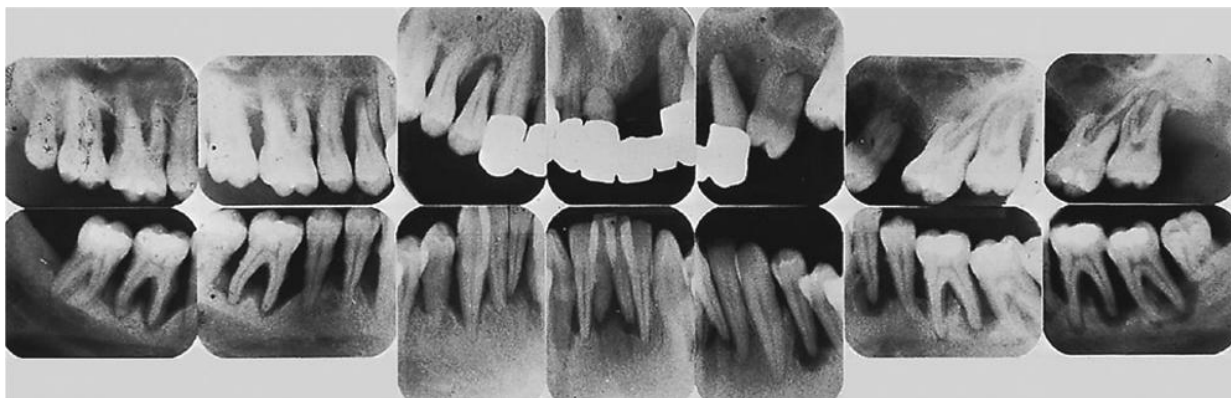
Case B, 26-year-old male. Radiographs showing the periodontal conditions prior to therapy.
